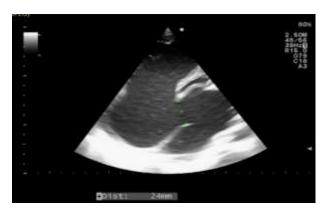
2D Echocardiogram showing atrial septal defect – ostium secundum type (subcostal view).
